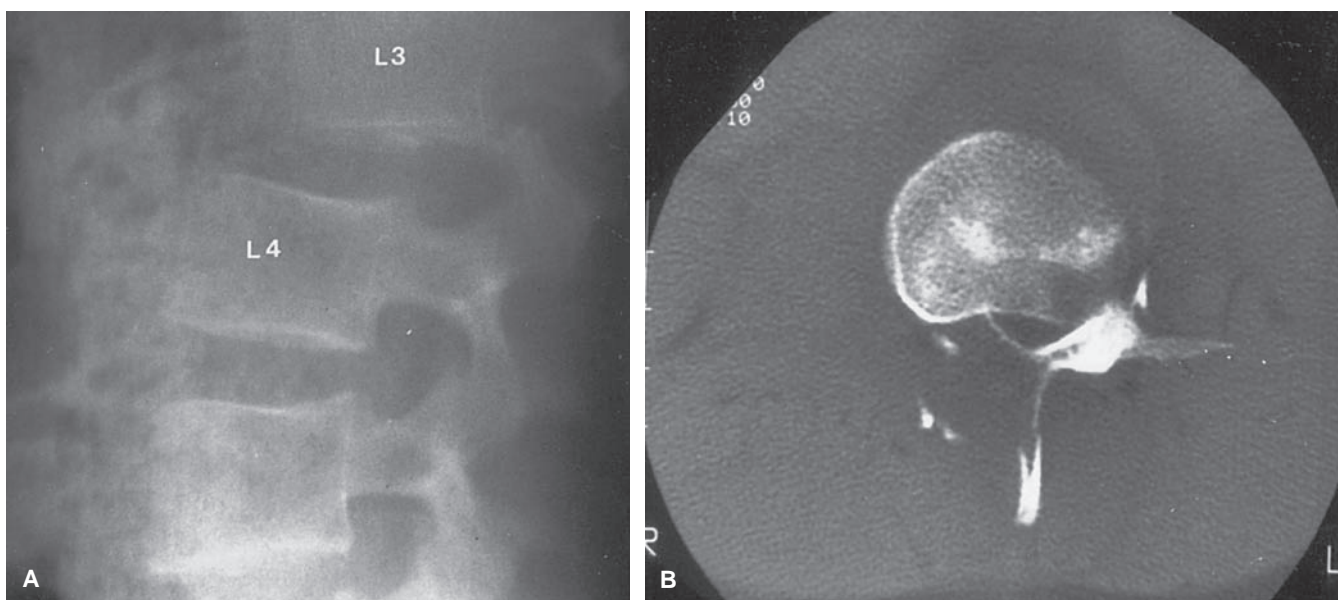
A: Fracture dislocation of the third (L3) and fourth (L4) vertebrae in a 12-year-old girl, the result of a shear injury in a motor vehicle accident. B: Permanent paralysis of the lower extremities resulted, as suggested by the degree of spinal canal collapse seen on the computed tomography scan.
